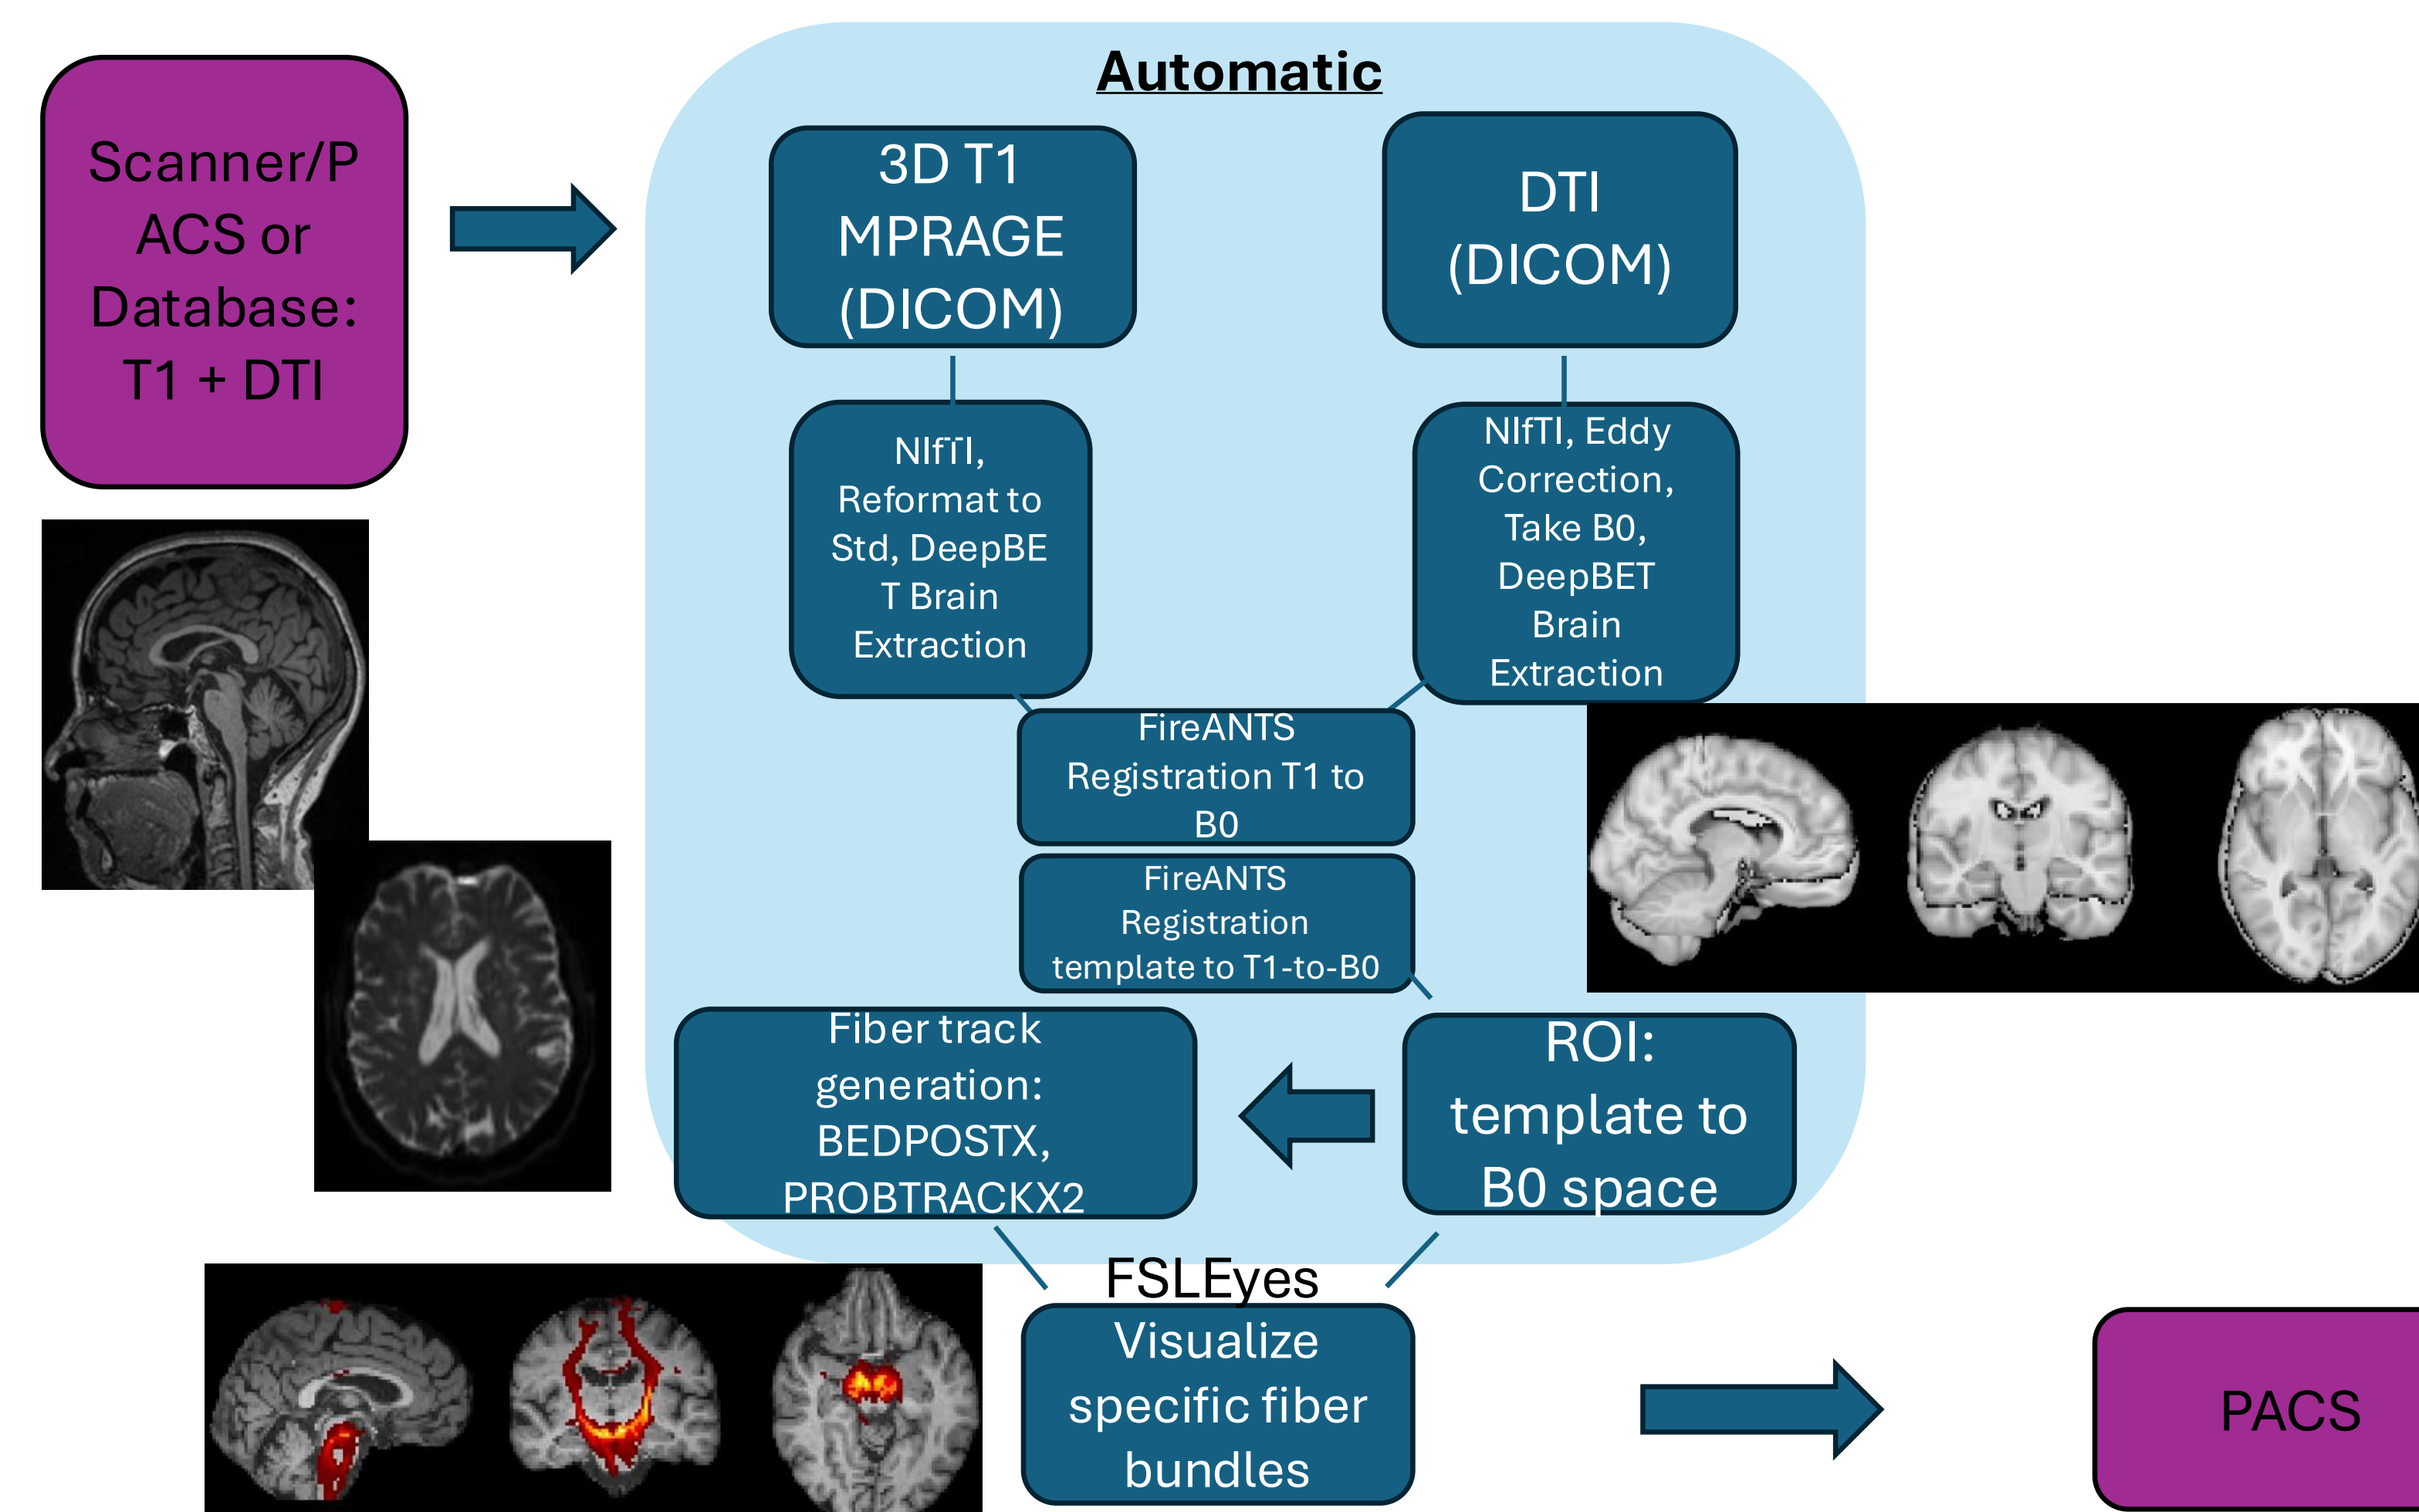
An automated post-processing system for brain fiber tracking that connects directly to the scanner PACS, MRI scanner, or DTI DICOM imaging database.
